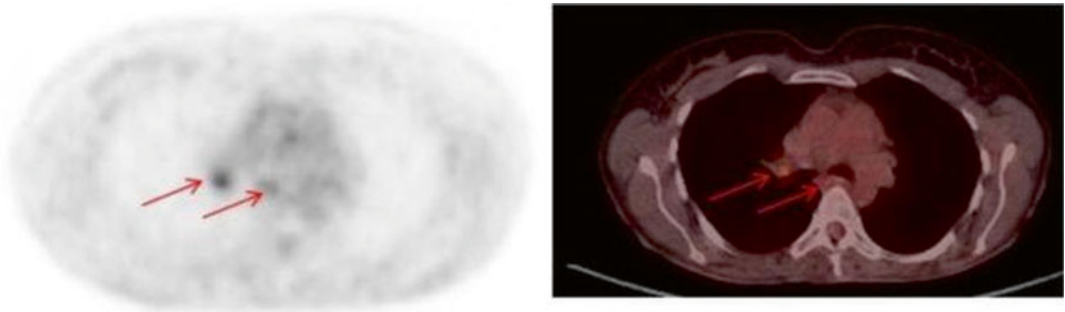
PET/CT after IGEV salvage chemotherapy. Mild hypermetabolism at subcarinal and right hilar lymph nodes
